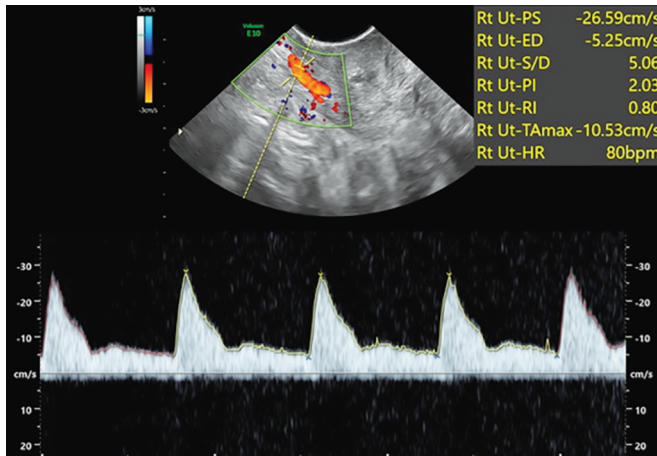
Doppler with notch
